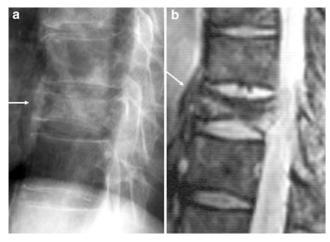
(a) Preoperative lateral plain X-ray of the thoracic spine showed T10 vertebral collapse (arrow). (b) Irregular high-intensity signal on T2-weighted magnetic resonance image (arrow)
